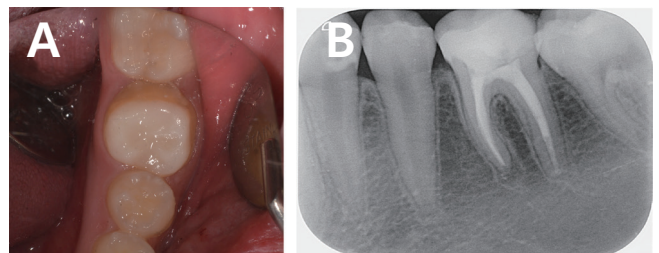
(A) Occlusal view of a clinical follow-up after 2 years, (B) Radiographic image after a 2-year follow-up.
